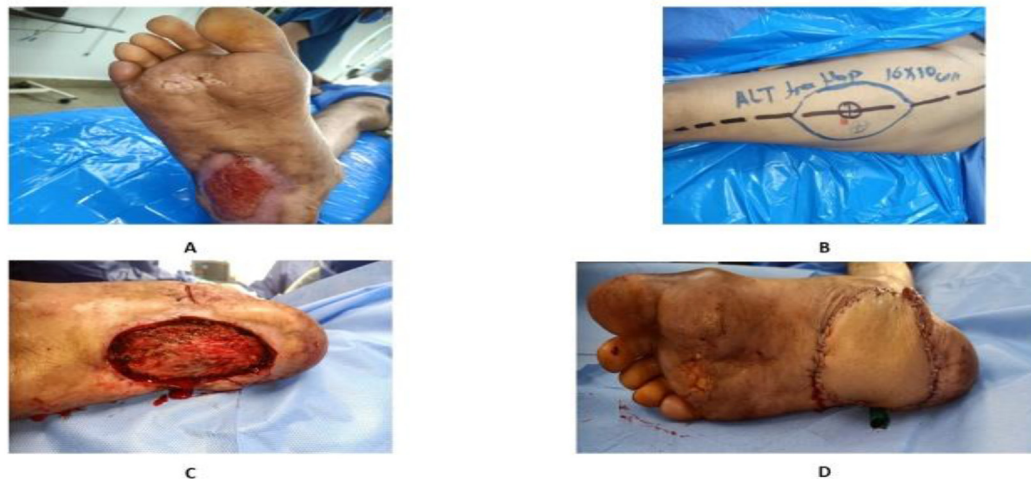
(A) Preoperative photo 46 years old man with diabetic ulcer at the soul of right foot, (B) Marking of doner (anterolateral thigh) flap by Doppler, (C) Debridement of the ulcer, (D) Immediate post operative.
